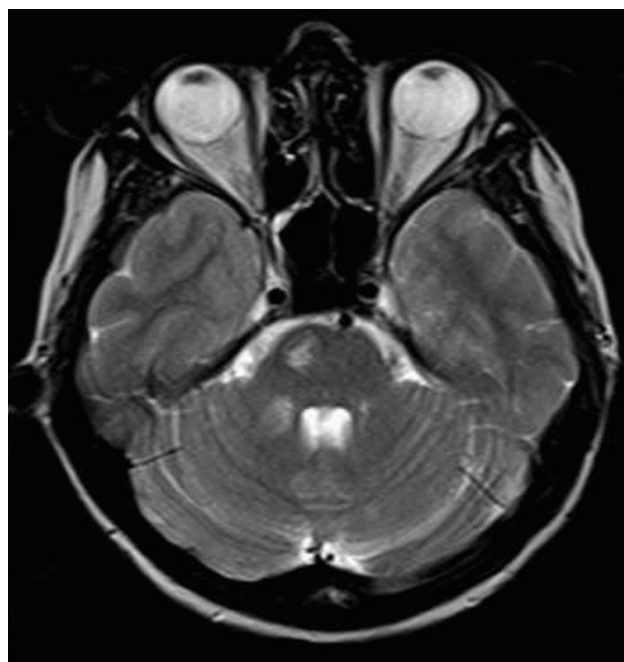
T2-weighted magnetic resonance imaging reveals hyperintense lesions at the right side of the pons and cerebellar peduncle.
